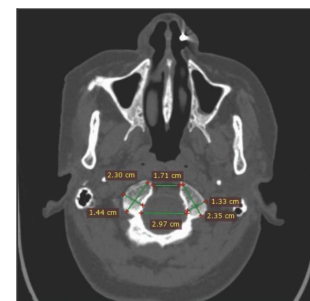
CT Scan image showing measurements of length and breadth of right and left occipital condyles (LROC, WROC, LLOC, WLLOC), minimum intercondylar distance (MnICD), maximum intercondylar distance (MxICD).
